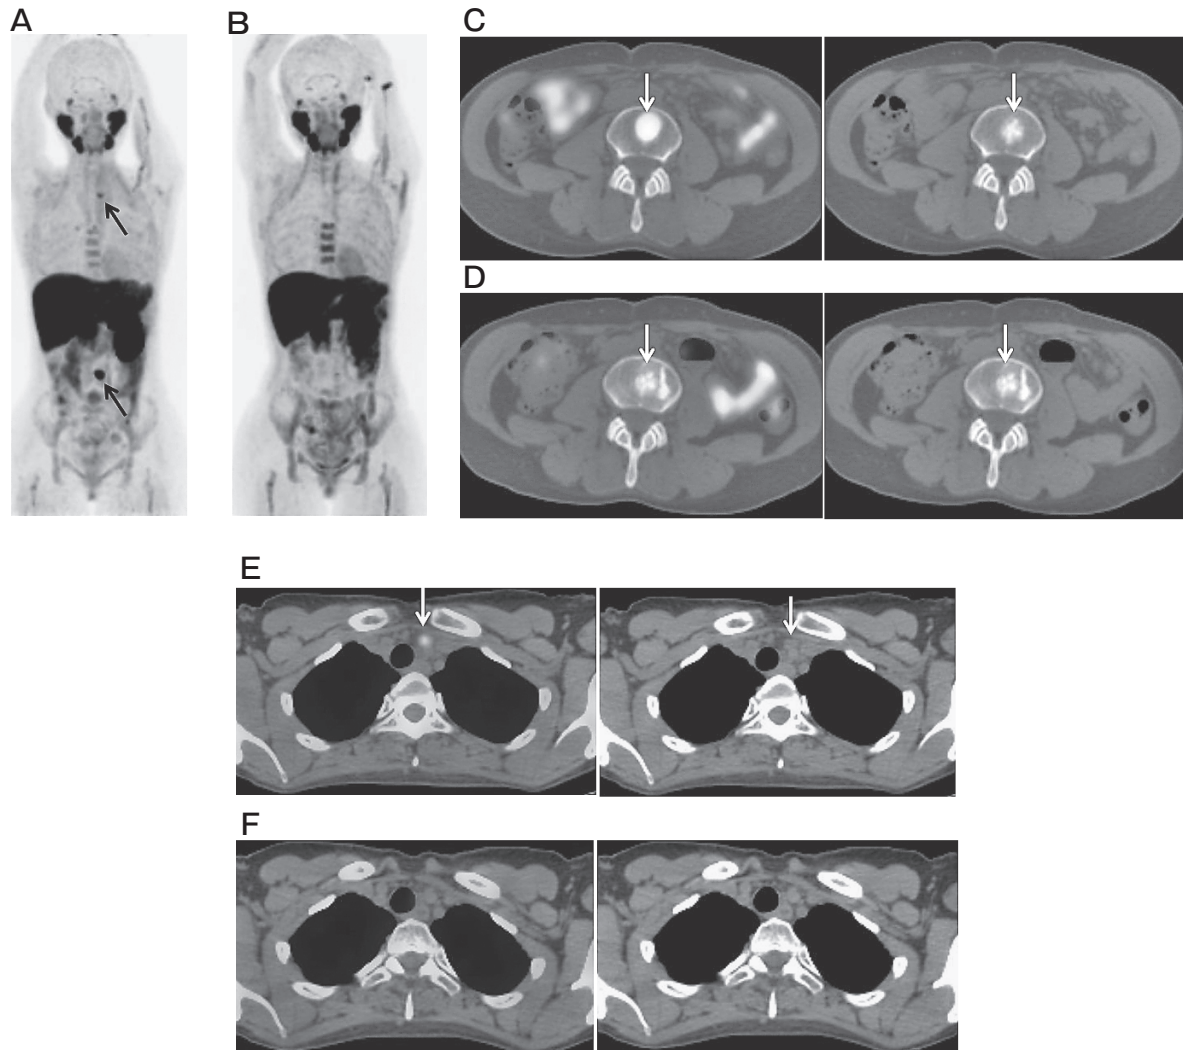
Representative case of a 44-year-old woman with renal cell carcinoma after surgery for the primary tumor, molecular target therapy, and radiation therapy of mediastinal lymph node recurrence and lumbar L4 vertebra bone metastasis. A, Maximum intensity projection (MIP) from baseline ^{11}C -choline PET/CT shows two abnormal ^{11}C -choline uptakes in the mediastinum and lumbar spine (arrows); B, MIP from ^{11}C -choline PET/CT after radiofrequency ablation and molecular target therapy shows disappearance of two abnormal ^{11}C -choline uptakes, reflecting a complete metabolic response (CMR); C, Baseline ^{11}C -choline PET/CT and CT show strong ^{11}C -choline uptake (maximum standardized uptake value (SUVmax), 8.41) and sclerosing change of L4 vertebra (arrow), suggesting recurrence of bone metastasis; D, ^{11}C -choline PET/CT and CT after radiofrequency ablation and molecular target therapy show disappearance of the abnormal ^{11}C -choline uptake (arrow), suggesting viable tumor disappearance (CMR); E, Baseline ^{11}C -choline PET/CT and CT show mild ^{11}C -choline uptake (SUVmax, 3.7) and a small mediastinal lymph node measuring 6×9 mm (arrow), suggesting recurrence of lymph node metastasis; F, ^{11}C -choline PET/CT and CT after molecular target therapy show disappearance of the abnormal ^{11}C -choline uptake (arrow), suggesting viable tumor disappearance (CMR).
